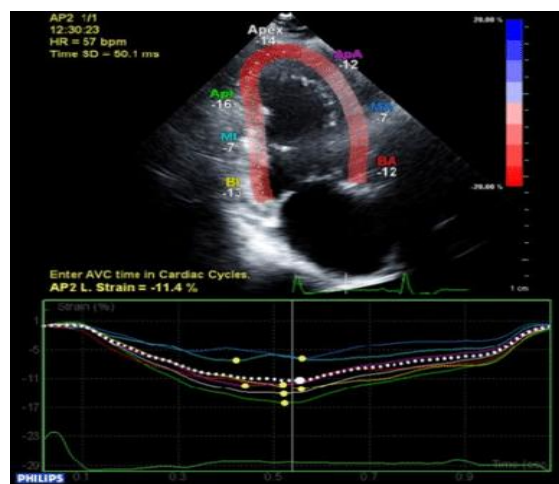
2D- Echocardiography
